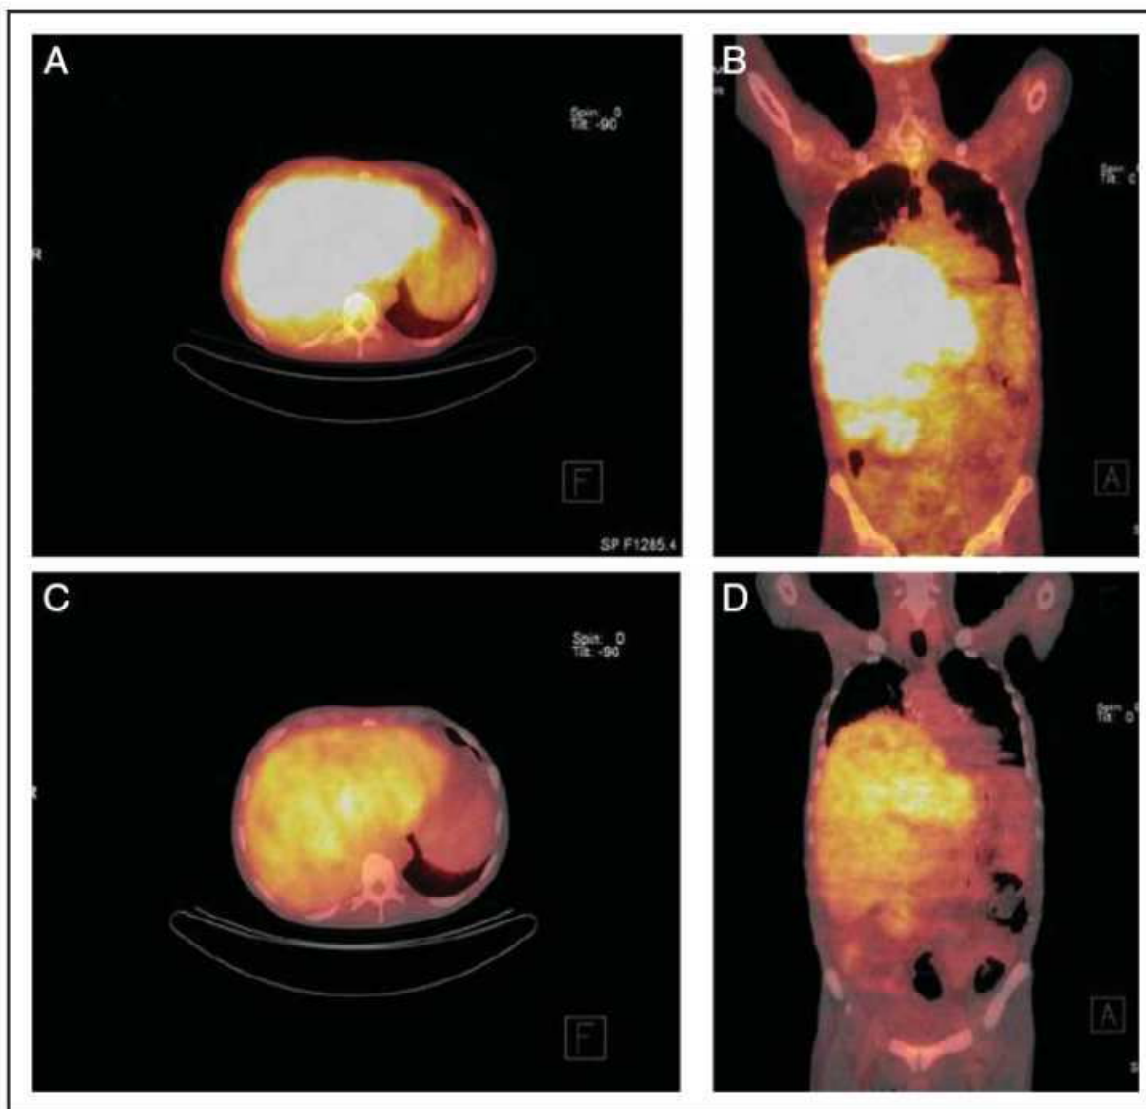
Objective response to Epstein-Barr virus (EBV)-targeted cytotoxic T-lymphocyte (CTL) therapy in patient 7. (A and B) Computed tomography-aided positron emission tomography imaging before T-cell therapy shows massive liver involvement. (C and D) After 3 months of EBV-targeted CTL therapy, reduction of size and isotope uptake of NPC lesions was detected.
